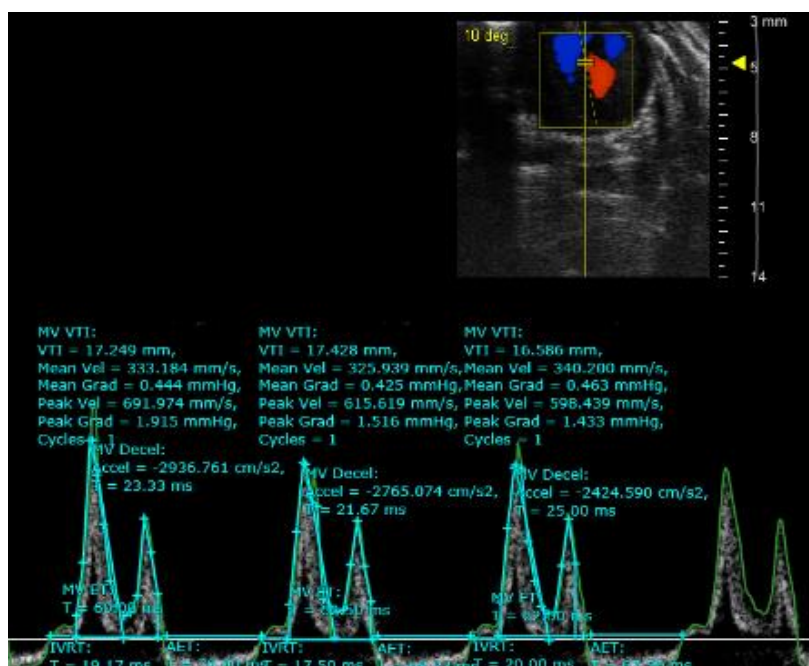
Apical 4 chamber view, with pulse wave Doppler (PW) of the mitral flow.
